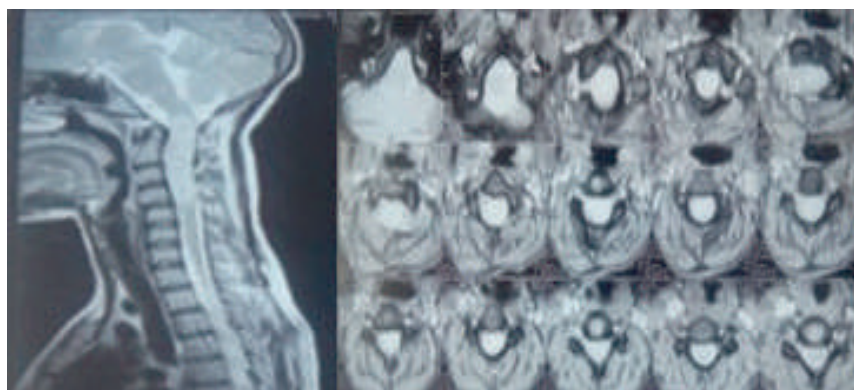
shows the sagittal section of T2 weighted MR image of this patient.
